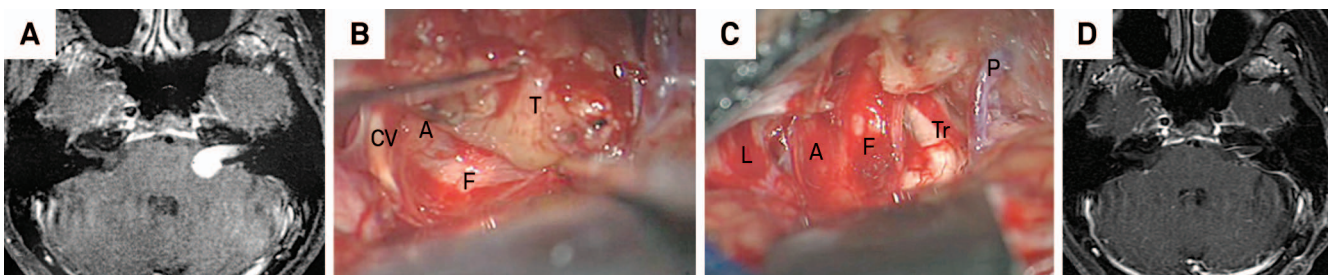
(A) VS in the left CPA; (B) The tumor (T) is dissected from the arachnoid (A) and the facial (F) and cochleo-vestibular (CV) nerves are barely seen through the membrane; (C) end result with the nerves protected by the arachnoid; and (D) Postoperative MRI demonstrating no residual tumor. F: Facial nerve; Tr: Trigeminal nerve; A: Arachnoid, P: Petrosal vein; L: Lower cranial nerves.
